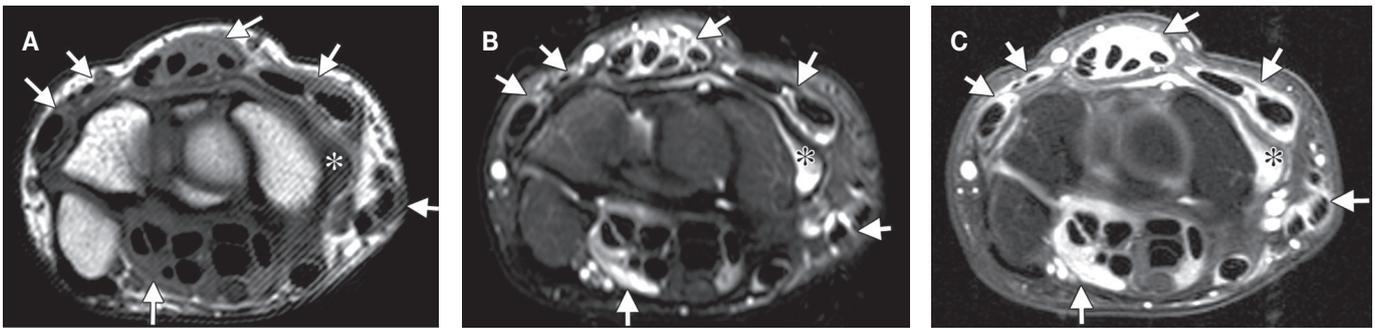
Tenosynovitis in early rheumatoid arthritis of the wrist (5 months duration) and normal radiographic findings. Axial T1-w (a), fat-suppressed T2-w (b), and contrast-enhanced fat-suppressed T1-w (c) MR images show marked tenosynovitis (arrows) involving both the dorsal extensor and volar flexor compartments and periscaphoid joint synovitis (*).
